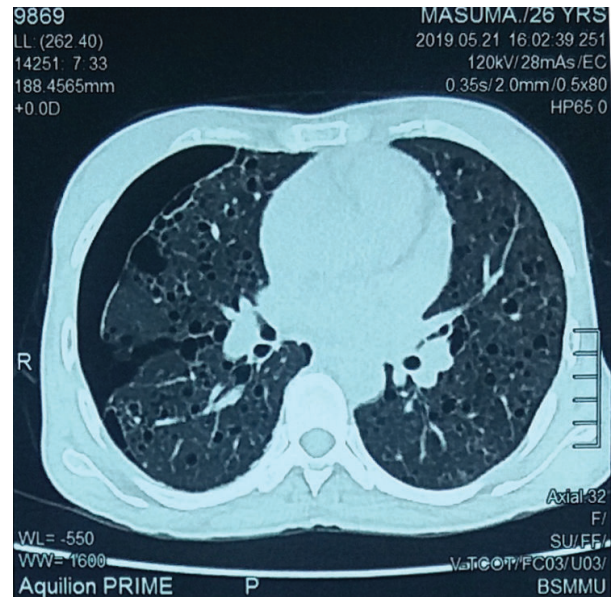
HRCT scan of chest revealed right sided pneumothorax with multiple thin walled cystic lesions with variable sizes in both lung fields
